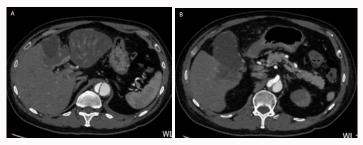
A and B: Follow-up computed tomography scans showing infarction of the right liver lobe and the gallbladder.
